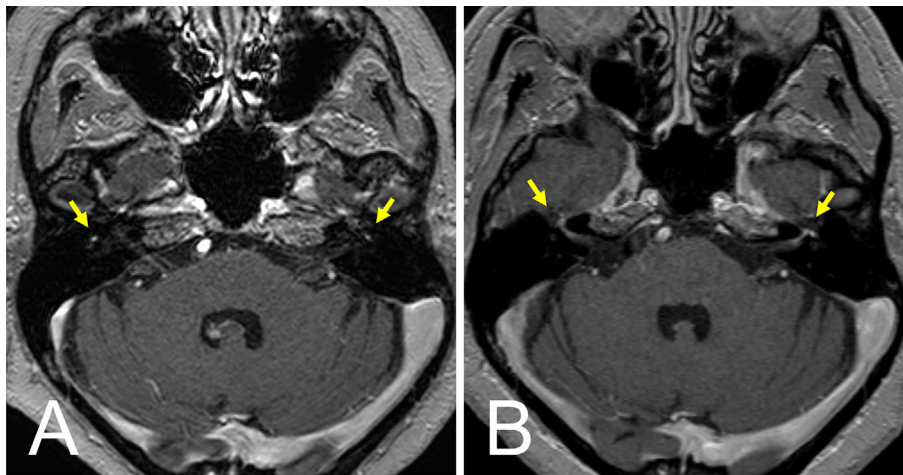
MRI showed a high signal on contrast-enhanced T1-weighted imaging in the bilateral tympanic segment of the facial nerves (A, arrows) and geniculate ganglions (B, arrows).
